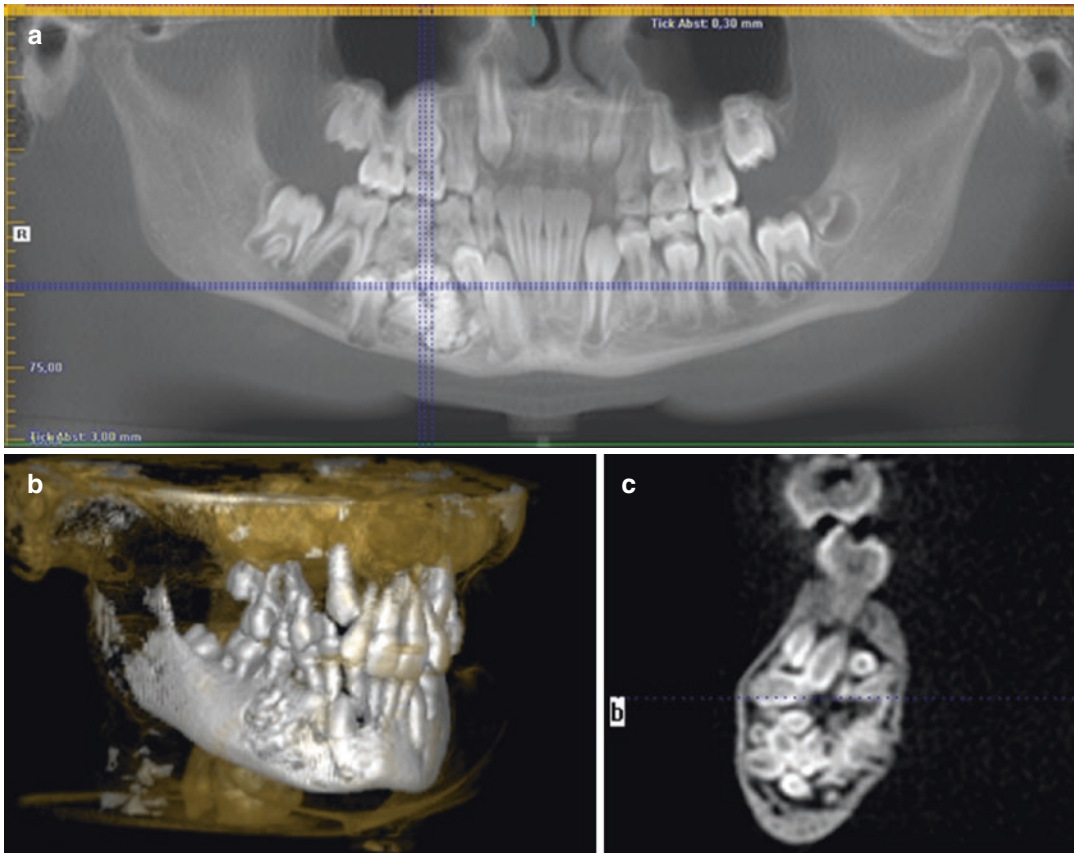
(a) OPT, (b) CBCT and cross-sectional radiograph of dental malformations. The high number of complex teeth-Anlagen represents a temporal, spatial, and ectodermal-mesodermal tissue dys-development. (Source: Ulrich Meyer, informed consent of patient exists). (c)
